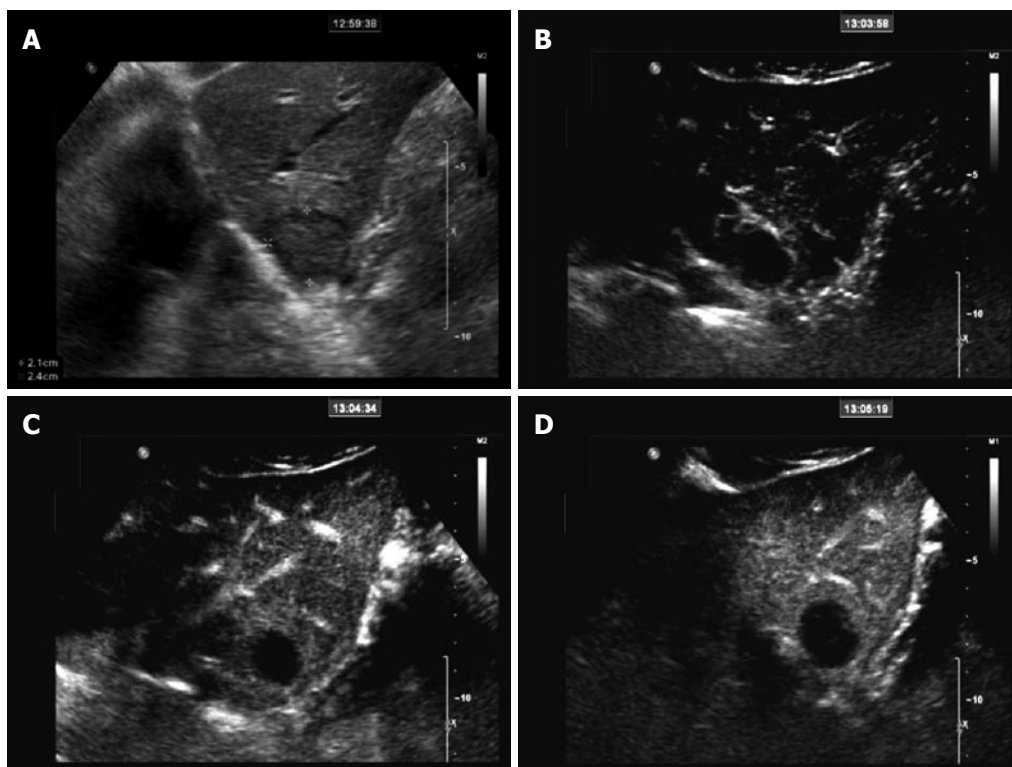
44-year-old male patient with a history of rectal carcinoma. A: 2.4 cm isoechoic lesion in segment 2/3 found in B-Mode sonography; B: Contrast-enhanced sonography with SonoVue® showed a distinct rim enhancement in the peripheral zone of the lesion 13 s after injection, representing the abnormal arterial supply of the lesion; C: Early washout of the contrast enhancement in the portal phase and lack of any portal enhancement resulted in a hypo enhancement of the lesion compared to the surrounding normal liver tissue; D: In the late phase, complete lack of enhancement within the lesion (black spot) allows a clear discrimination of the lesion from the strongly enhanced normal liver tissue. The enhancement pattern is typical for a hypovascular metastasis.
